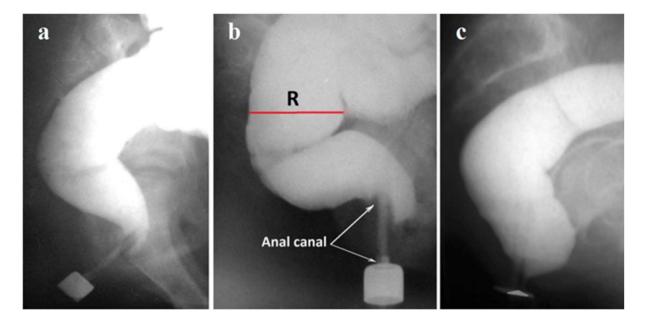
Lateral radiographs of anorectum in different patients without digestive system pathology. (a). In a 12-year-old patient, the length of the anal canal is 3.4 cm. As a result of the contraction of the PRM, the axis of the anal canal is displaced forward relative to the axis of the rectum with the formation of an acute rectoanal angle. (b). In a 9-year-old patient, the anal canal is 3.3 cm long. As a result of IAS relaxation, barium penetrated the upper part of the anal canal in front of the enema tip. The posterior wall in the upper part of the anal canal is pressed against the tip of the enema by contracted PRM. This is a picture of the rectoanal inhibitory reflex. Despite the relaxation of the IAS, barium (fecal) retention occurs because of the contraction of the PRM and EAS. (c). Under the influence of high pressure in the rectum, a wide opening of the anal canal occurred, which is due to the contraction of the levator plates. This attempt defecation was prevented by voluntary contraction of the subcutaneous portion of the EAS.
